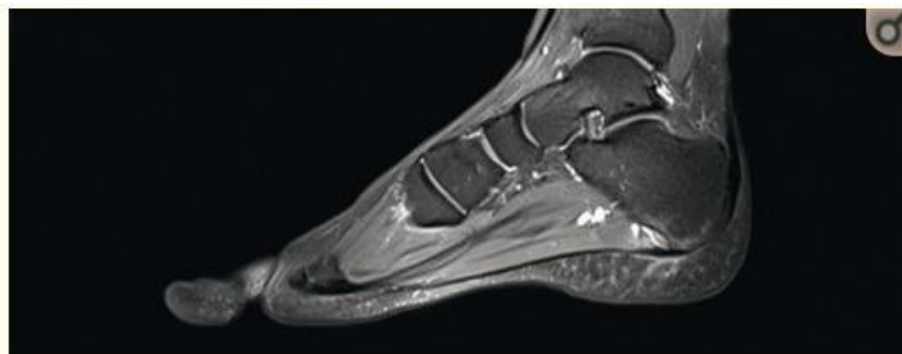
MRI of the foot: bone marrow edema in the plantar area, with thickening of the enthesis and swelling of adjacent fatty tissue.¹⁶
